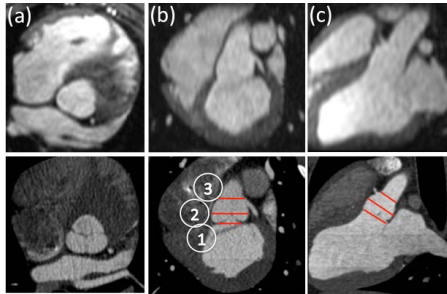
Axial (a), OS (b) and OC (c) LVOT reformats of 3D MR (top row) and CTA datasets (bottom row). Note: 1. annulus; 2. Max. diameter across sinuses; 3. ST junction.
